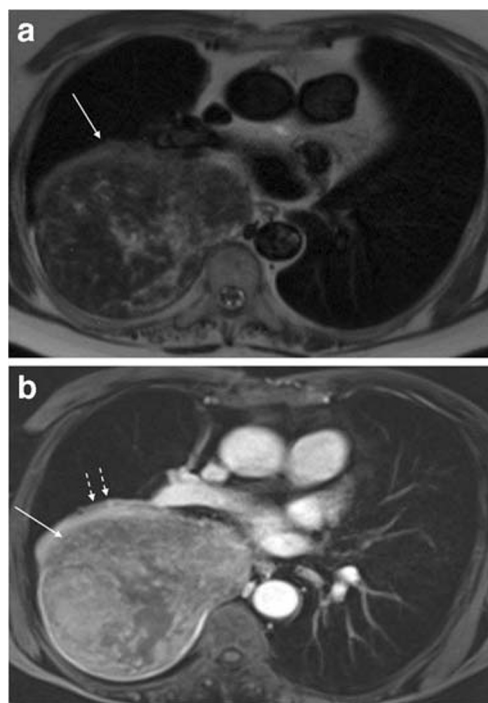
Malignant solitary fibrous tumor of the pleura in a 80-year-old woman. a Axial T2-weighted image shows a large predominantly T2 hypointense extrapulmonary mass (white arrow) in the posterior right hemithorax exerting mass effect on the adjacent right lung and mediastinum. b Post-contrast T1-weighted image shows heterogenous enhancement (white arrow) with associated compressive atelectasis in posterior right lung (dashed white arrows)
